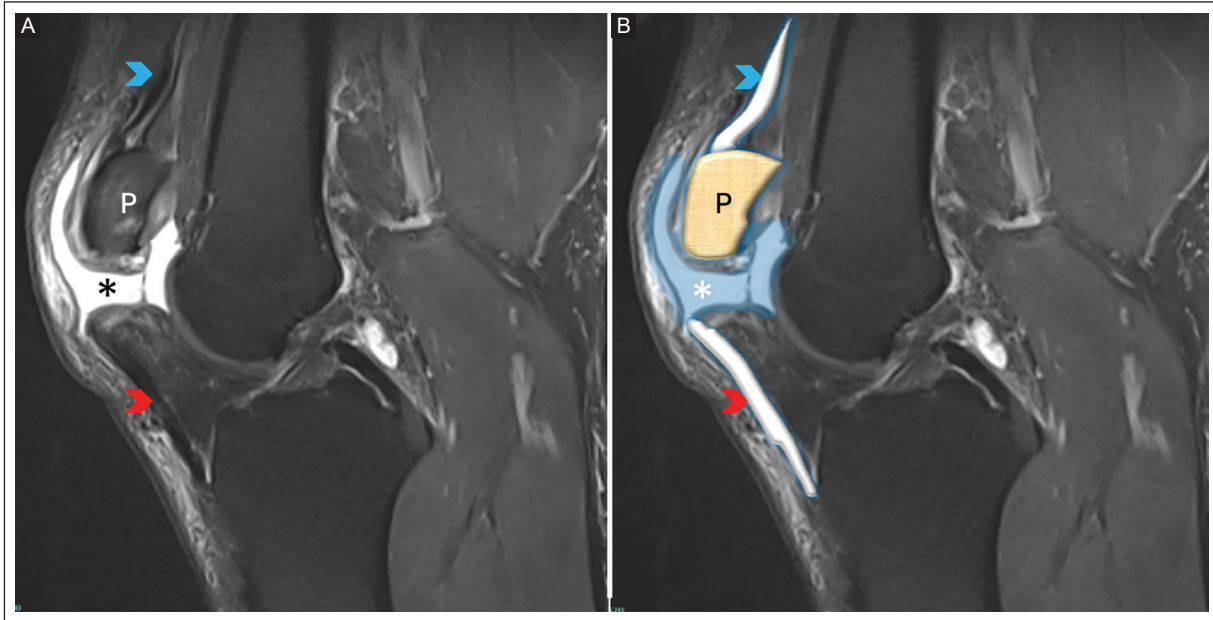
A-B: sagittal proton density-weighted knee MRI with fat suppression in a 42-year-old man shows complete patellar tendon rupture, characterized by fiber discontinuity and marked hyperintense fluid signal at the tear site (red arrowheads). There is abnormal hyperintense fluid communication between the knee joint and the superficial prepatellar bursa (asterisks), highlighted in blue. The patella is shown in brown. The quadriceps tendon is intact (blue arrowheads).
